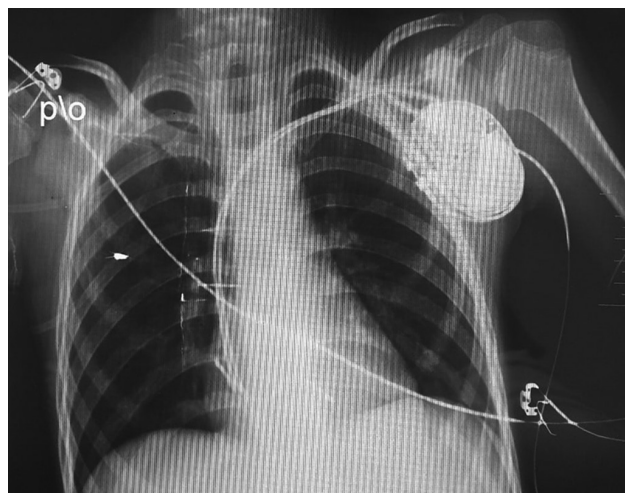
Chest radiograph of a patient after pacemaker implantation.
